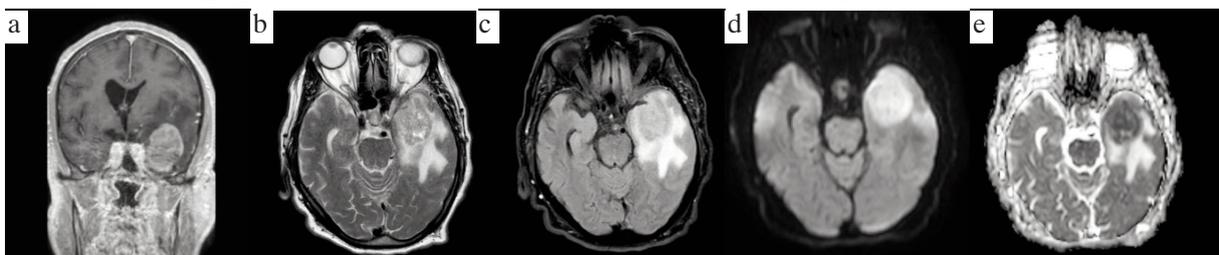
a-e: Intraaxial mass lesion in the left anterior temporal region on brain MRI. Iso-hypointensity on coronal T1-weighted images and subfalcine shift (a). Iso-hyperintensity on axial T2-weighted images (b). Extensive vasogenic edema in the left temporoparietal region on fluid-attenuated inversion recovery (FLAIR) images (c). Hyperintensity on transversal relaxation attenuated by controlled excitation (TRACE) images in diffusion-weighted images (d). Significant diffusion restriction in the apparent diffusion coefficient (ADC) map on diffusion-weighted images (e).
